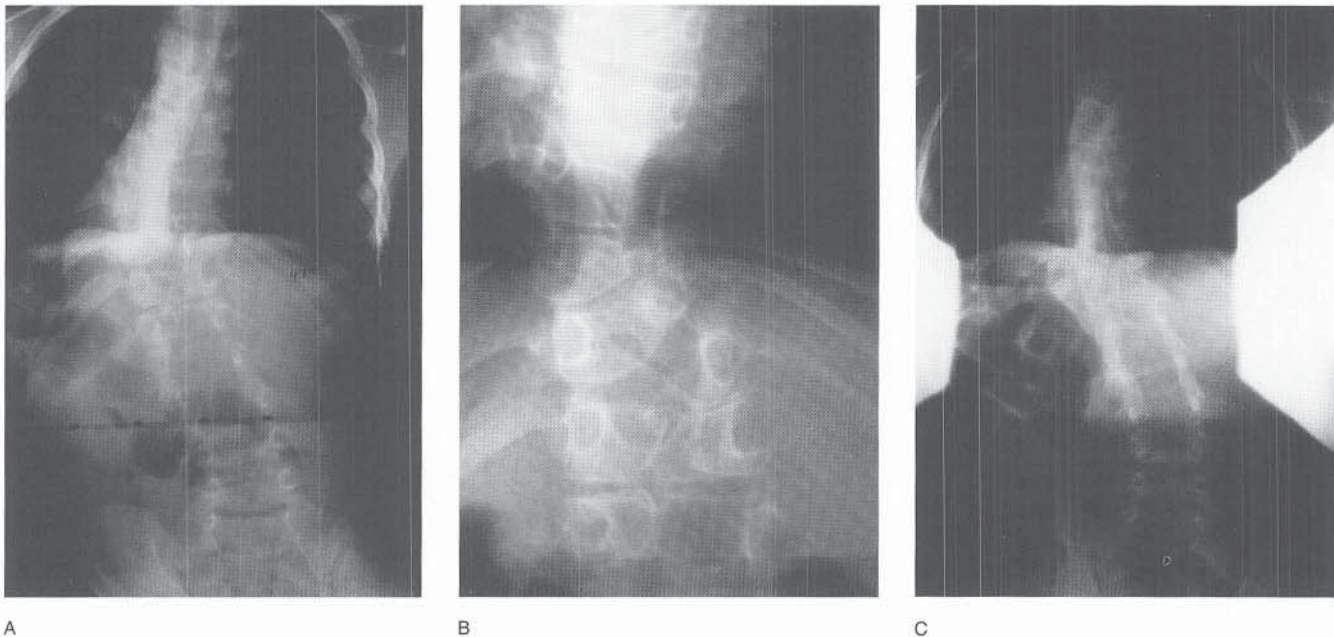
A neurologically normal 6-year-old girl had a left congenital thoracic curve measuring 47 degrees (A). It had increased a small amount (6 degrees) over 4 months. The decision was made to operate before a major deformity developed. The preoperative bending radiograph clearly demonstrated a bar formation in the concavity at T8-10 (B). (Five years previously the patient had undergone resection of a diastematomyelia at the thoracolumbar junction.) Anterior and posterior fusion without instrumentation was performed. After surgery the patient was immobilized for 4 months in a Risser cast. Four years later the curve measured 25 degrees, she had good spinal balance, and she remained neurologically normal (C).
